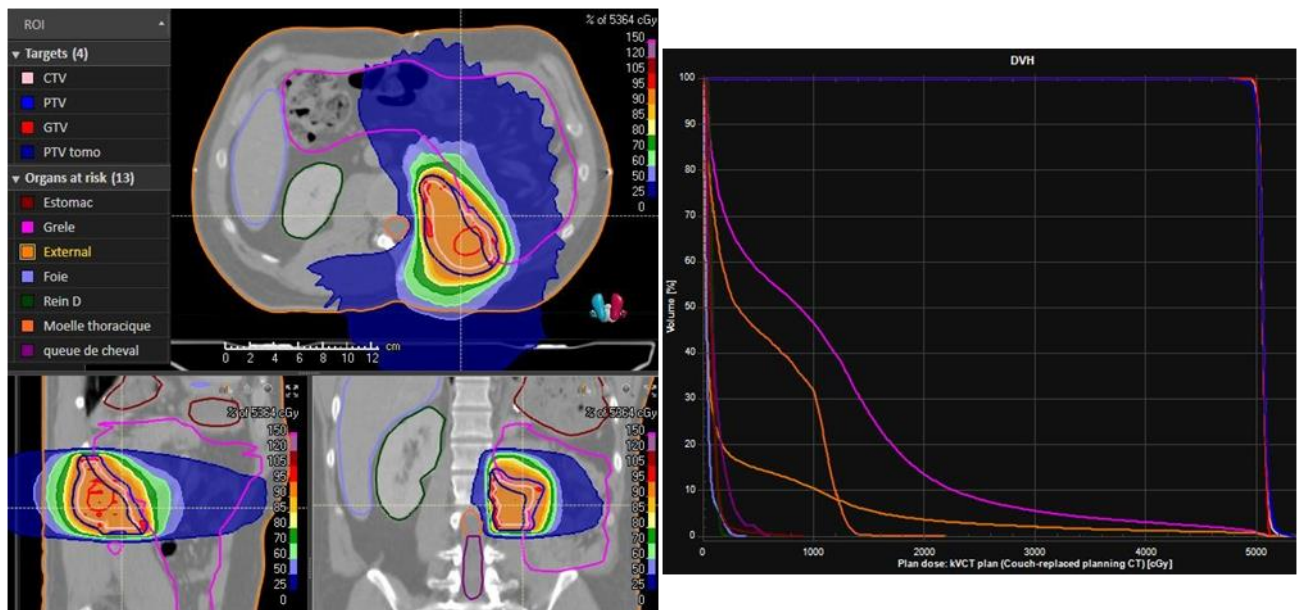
Typical interface of a TPS: on the left the user visualizes the CT images with the isodose lines superimposed in colors, and the list of ROIs on the left. The right part shows the DVH curve for each of the ROIs in the list: the targets appear as steep lines at the right of the graph (homogeneous doses), whereas the OARs show smoother curves with various dose levels depending on the sparing reached for this specific plan (RayStation, RaySearch Laboratories).
